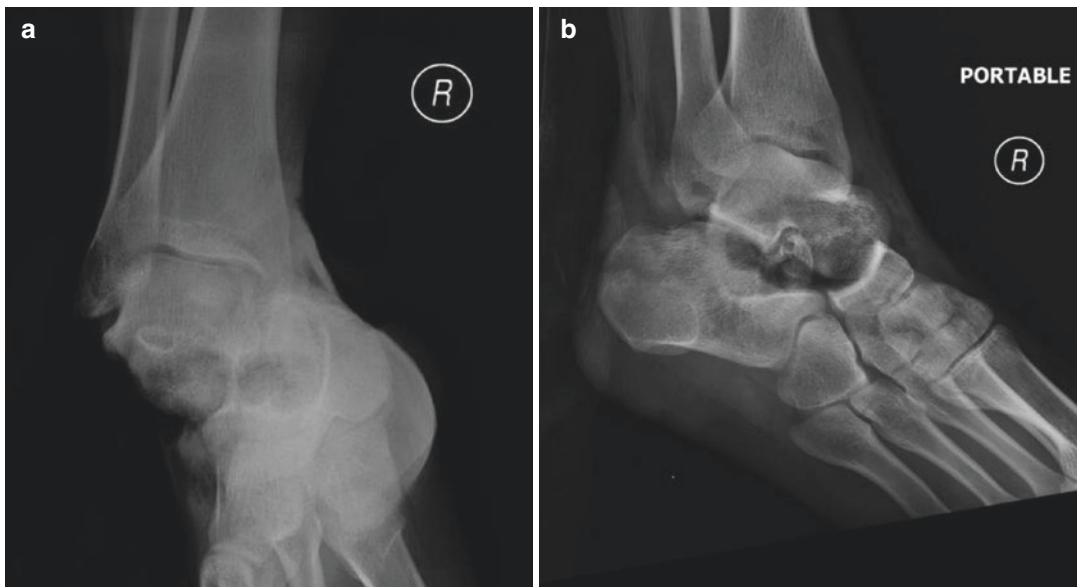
(a, b) Injury films for Case 2. “Presenting injury radiographs demonstrating a medial subtalar fracture dislocation”
